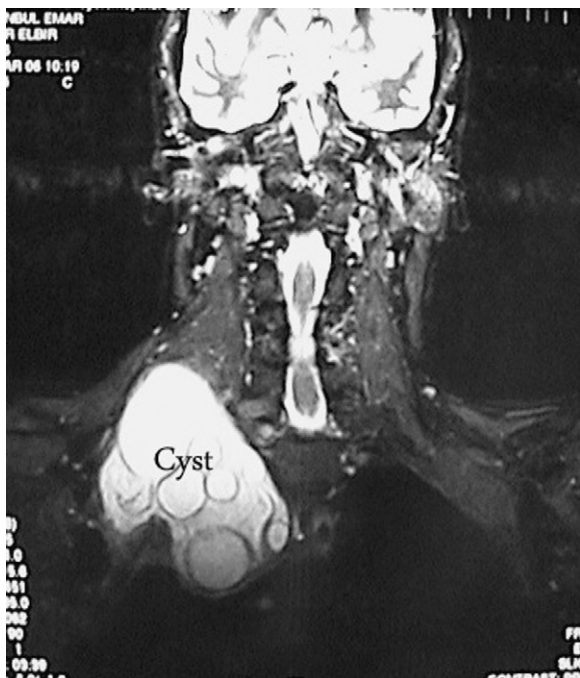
Magnetic resonance imaging indicating a lobulated mass localised to the chest wall at the thoracic inlet protruding from the chest to the neck.
